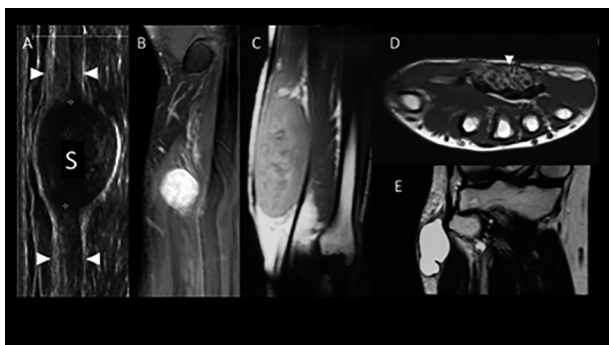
Imaging of the solitary peripheral nerve tumours using ultrasound and magnetic resonance imaging (MRI). A) Ulnar nerve Schwannoma at the wrist. Ultrasound shows an isolated globoid mass located along the nerve and eccentric to the nerve axis with a homogeneously hypo-echoic structure without posterior acoustic enhancement. white arrows= nerve. B) Ulnar nerve Schwannoma at the wrist. Coronal T1-weighted fat-saturated MRI following intravenous (IV) contrast, shows an eccentric globular mass with diffuse enhancement, in direct continuity with nerve at its proximal and distal poles. C) Median nerve neurofibroma at the wrist. Coronal T1-weighted fat-saturated MRI following IV contrast shows a fusiform swelling with heterogeneous enhancement. D) Fibrolipomatous hamartoma of the median nerve at the wrist. Axial T1-weighted MRI shows thickened and hypodense nerve fascicles surrounded by hyperintense fibro-adipose tissue giving it a coaxial ‘cable-like’ appearance of the lesion (white arrow). E) Intra-neural ganglion cyst of the common peroneal nerve. Coronal T2-weighted MRI shows the fluid nature of the tumour, and its cystic nature, arising from the superior tibiofibular joint.
